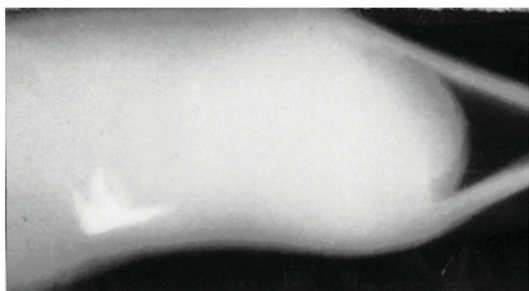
Soft tissue X-ray showing calcification of penile plaque.
